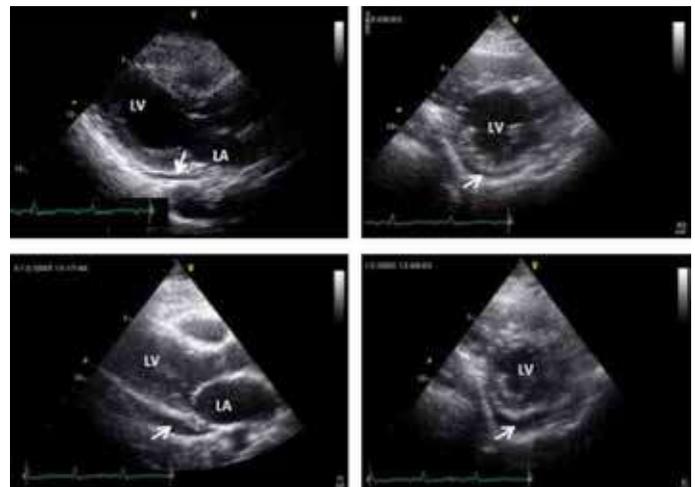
Posterior SPE in a 68-year old female patient affected by CAP. The grading of pericardial effusion takes into account the diastolic separation between epicardium and pericardium: small ≤10 mm, moderate = 10-20 mm, severe ≥20 mm. In this patient the diastolic separation is ≤10 mm (both in long and in short-axis vies), indicating SPE (arrows). Upper panel: visualization of diastolic pericardial effusion in parasternal long-axis (left panel) and short-axis view (right panel). Lower panel: visualization of systolic pericardial effusion in parasternal long-axis (left panel) and short-axis view (right panel). LV: left ventricle, LA: left atrium.
